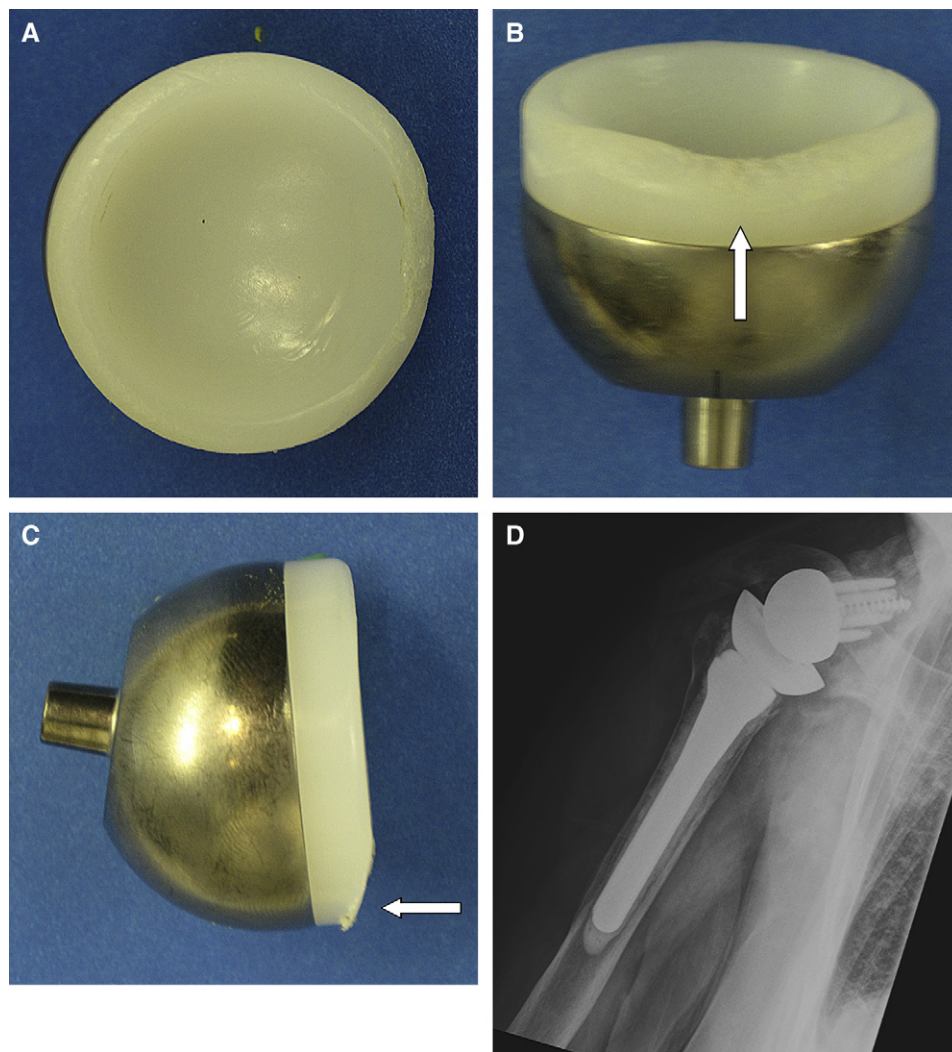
(A) Humeral polyethylene demonstrates scratching and pitting consistent with adhesive surface wear. (B, C) Humeral polyethylene demonstrates abrasive wear in the inferior quadrant consistent with a clinical adduction deficit (D). Anteroposterior radiograph of the implant shown in Panels B and C is consistent with scapular notching.
